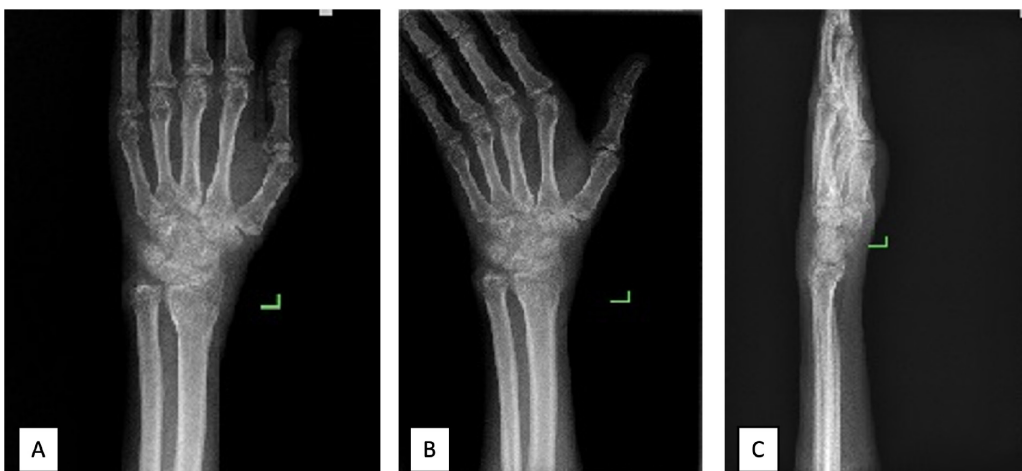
Non-union in the proximal 1/3 of the scaphoid bone A) AP X-ray, B) AP X-ray in ulnar deviation, C) Lateral X-ray
